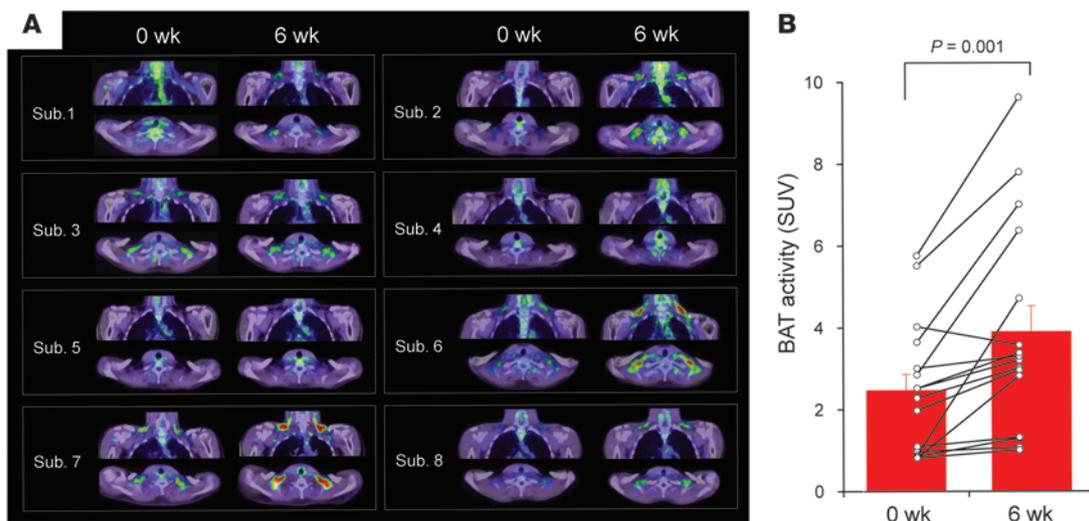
BAT recruitment by chronic cold exposure. FDG-PET/CT images (A) and BAT activity (B) of 8 subjects before and after the 6-week daily cold exposure. SUV of both sides of the neck was plotted.
